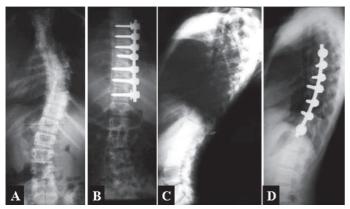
Preoperative (A and C) and postoperative (B and D) radiographic images from a patient who underwent posterior instrumentation.
